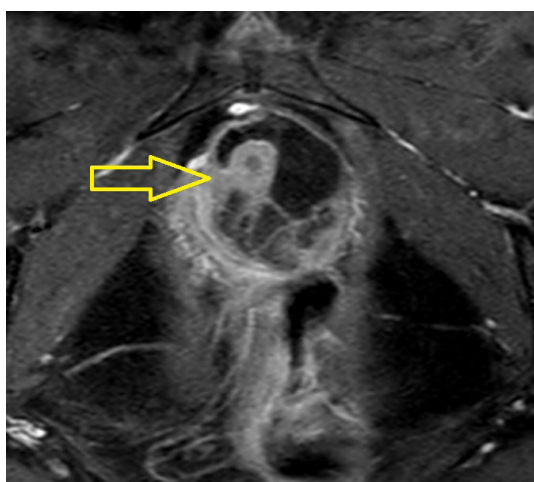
T1-weighted post-contrast axial magnetic resonance imaging depicting peripheral heterogeneous enhancement of the diverticulum.
